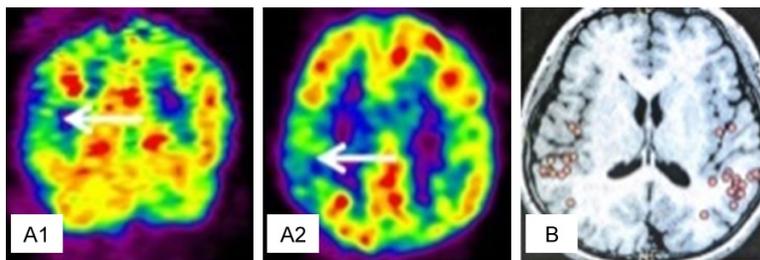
A. Hypometabolism in the right parietal lobe in the coronal (A1) and axial (A2) interictal FDG-PET scans (arrow). B. The epileptogenic foci were localized in the bilateral occipito-temporal area in the axial interictal MEG (red dots).
